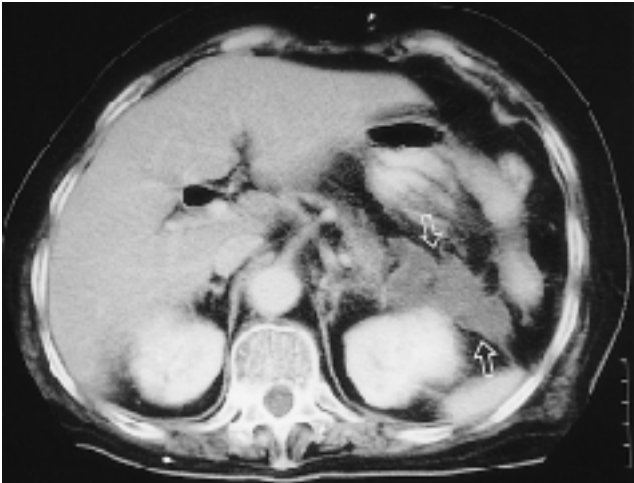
70-year-old woman with acute pancreatitis which developed after laparoscopic proctosigmoidectomy with coloanal anastomosis. Contrast-enhanced CT scan shows septated fluid collection in peripancreatic region (open arrows), suggesting the presence of acute pancreatitis.
